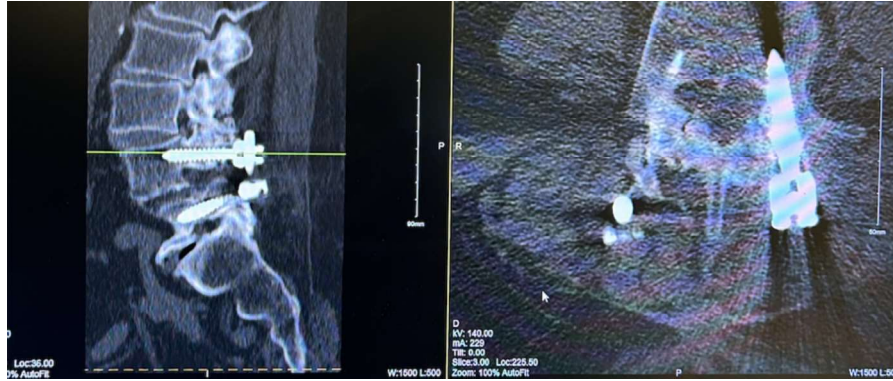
Sagittal and Axial CT Post-Surgical Intervention in 2010.
